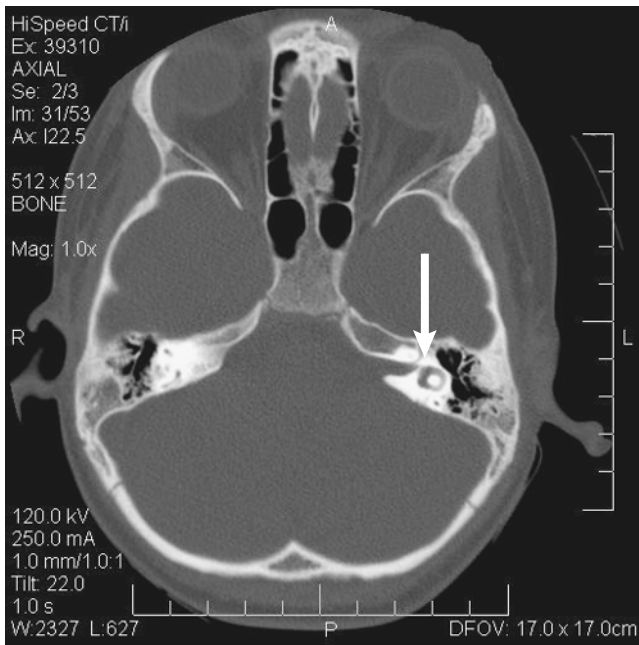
Bill's bar (arrow) separating the facial nerve from the superior vestibular nerve (computed tomographic scan, axial cut).
